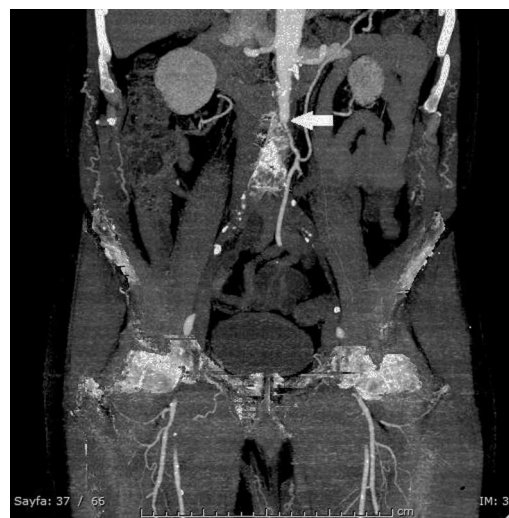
In the coronal section of the intravenous contrast-enhanced abdominal CT; initial localization of the infrarenal occlusion in the abdominal aorta (arrow).
